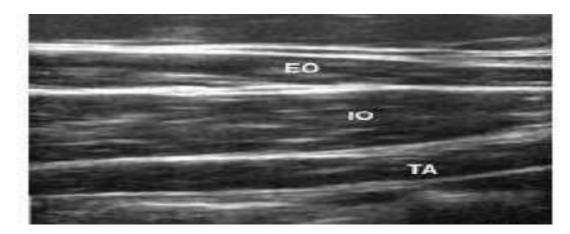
Ultrasound anatomy for performing the TAP Block. EO: External Oblique Muscle; IO: Internal Oblique Muscle; TA: Transversus Abdominis
